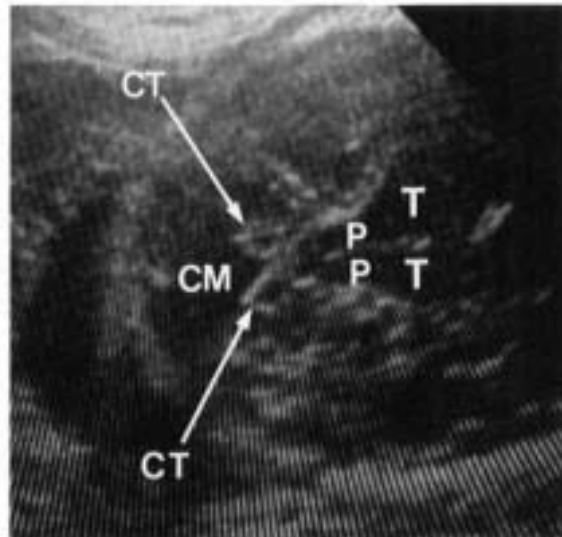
Because of the large cisterna magna (CM), the cerebellar tonsils (CT) that lie between the posterior aspect of the medulla oblongata and the cerebellar vermis are clearly defined in this view of the fetal head.
